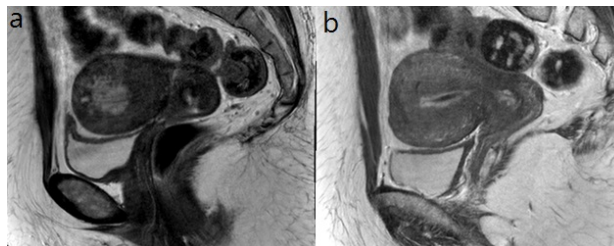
T2-weighted MRI at the time of diagnosis and three months after treatment. (a) Sagittal view of preoperative MRI at the time of diagnosis. (b) Sagittal view of postoperative MRI, three months after the surgery.
